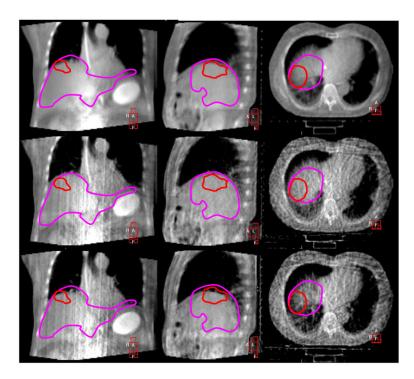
An example of a kV 4D CBCT reconstruction acquired while the patient was breathing. Top=all projections combined (the image appears blurry due to the breathing motion), middle=exhale sorted images, bottom=inhale sorted images. The planning contours are overlaid for reference: Purple=planning exhale CT liver, red=GTV
